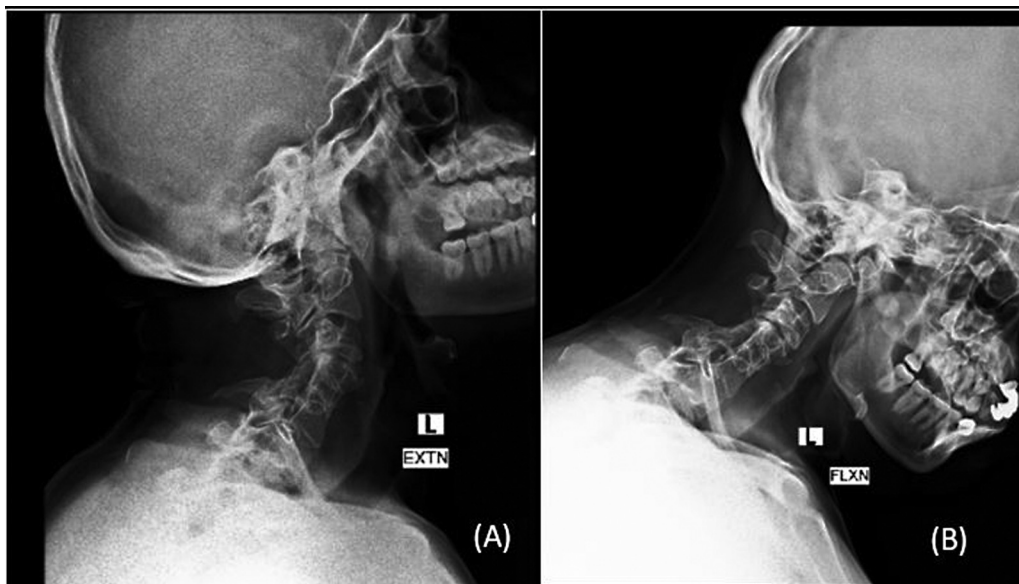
Lateral (A) extension and (B) flexion radiographs showing no movement at the cervical block vertebrae.
